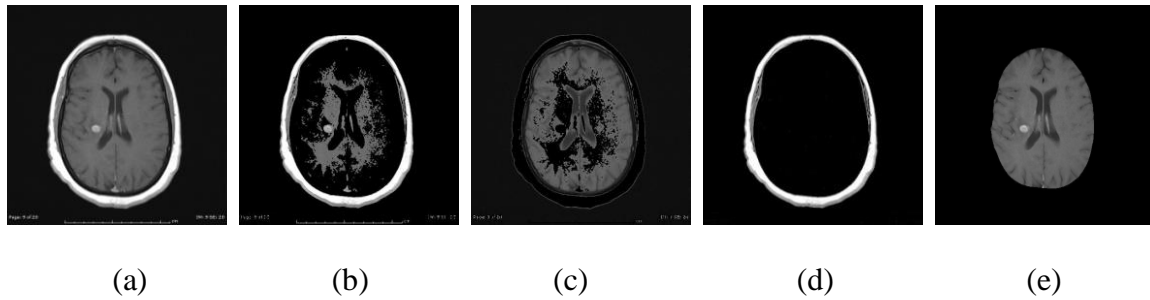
(a) Original MRI image, (b-c) Images after thresholding, (d) Extracranial mask, (e) Intracranial Mask
